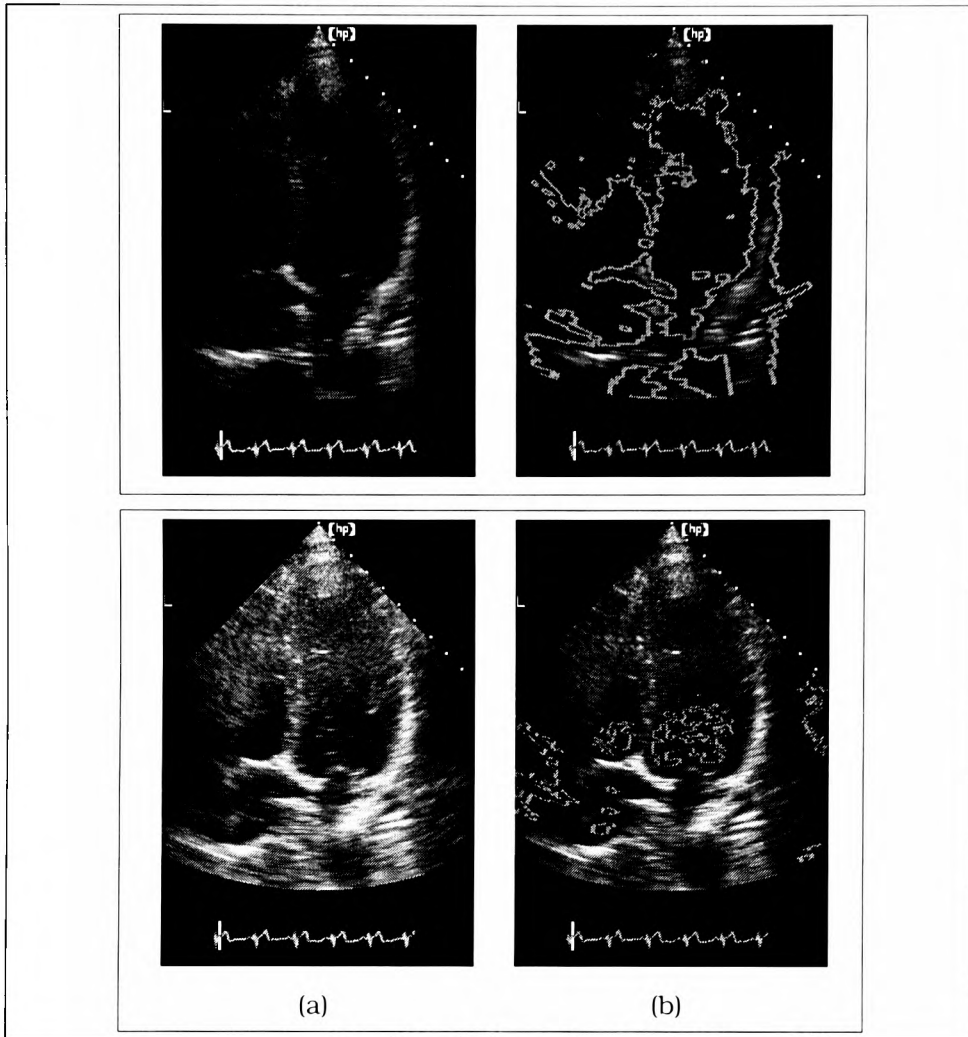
Acoustic Quantification. Acoustic Quantification (AQ) is based on automated boundary detection which discriminates boundaries using discontinuities in the radio-frequency (RF) signal returning from the tissue. Pixels with discontinuities above a user-defined threshold are marked as boundary points. Pixels labelled as boundary points are then joined together to form a connected boundaries. (a) Echocardiographic image. (b) Corresponding AQ image. Note how in the top figure, the connected boundary extends into the left atrium. In the bottom figure, the choice of threshold affects the labelled boundary.
